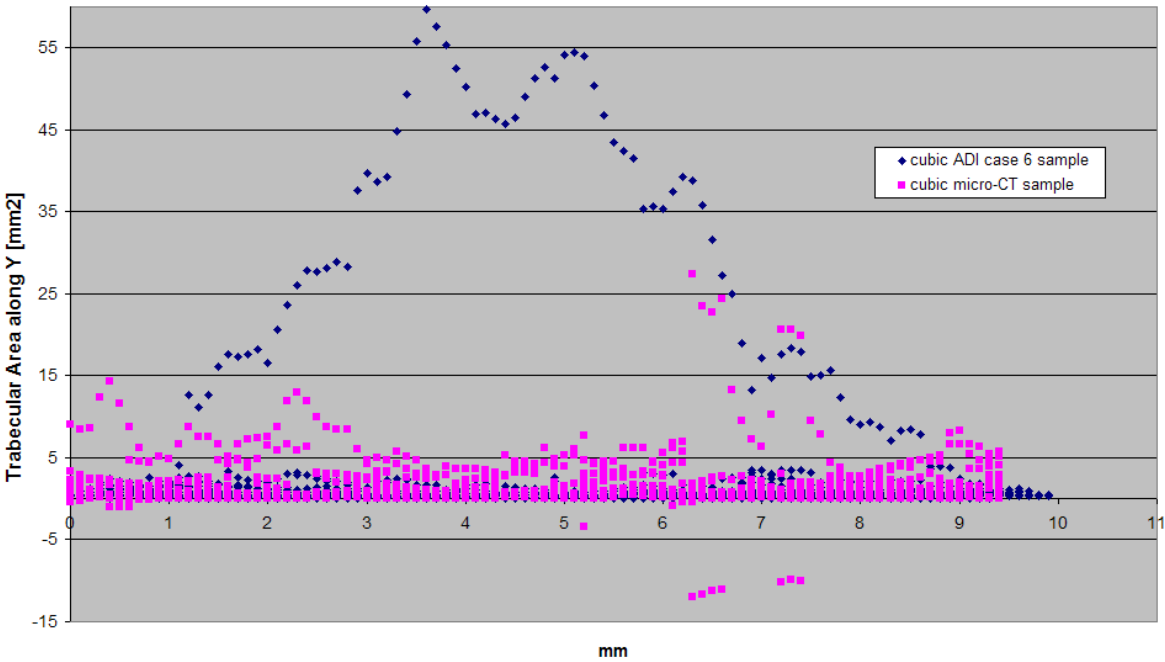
Comparison of sliced area along *Y* between the cubic ADI case 6 sample and cubic  $\mu$ CT sample
